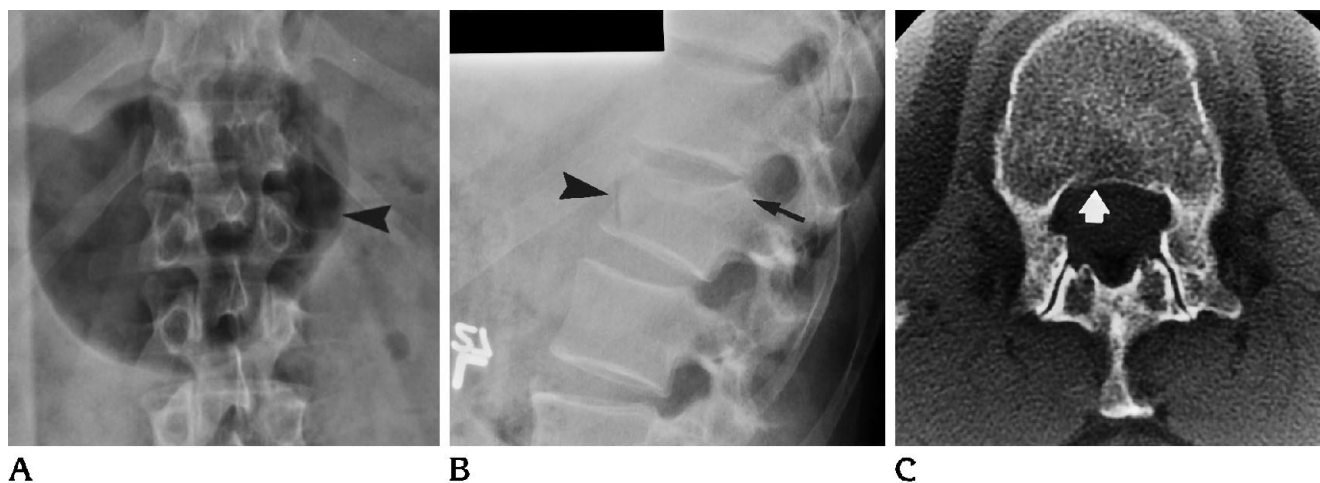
A and B, Plain films (anteroposterior and lateral) of an L-1 fracture (*large arrowheads*). Five of six plain-film readers called this stable. However, the posterior vertebral line is indistinct (*black arrow*) and could have been scored as a 3 (possibly unstable) if strictly following plain-film criteria.
